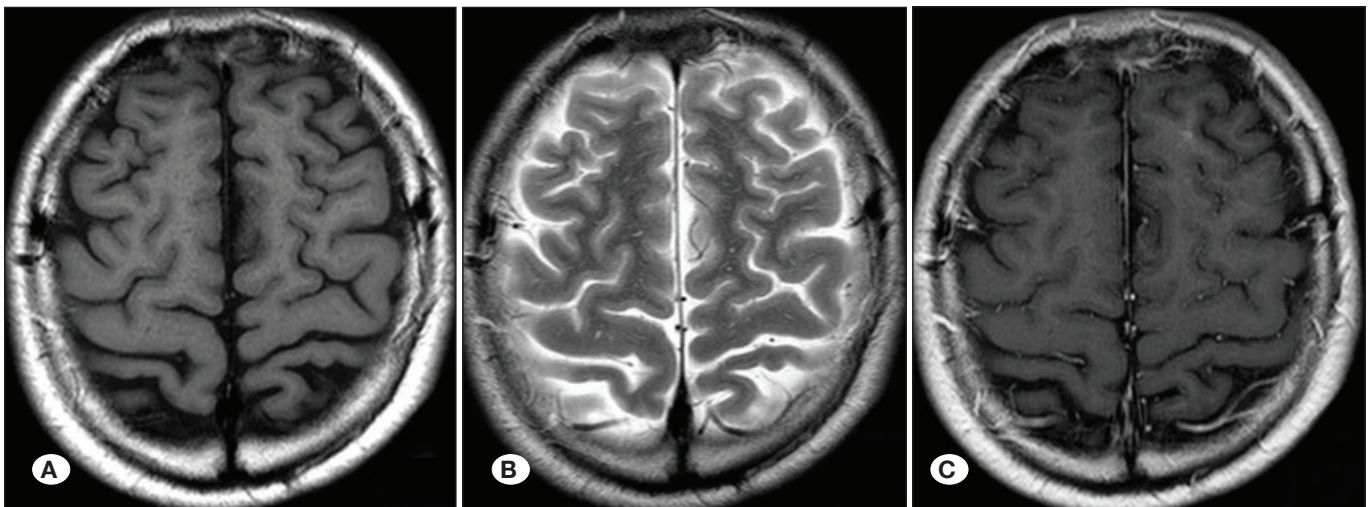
3rd year control cranial MRI. A) T1W axial, B) T2W axial, C) T1W axial+with contrast. No recurrent tumor was detected.
